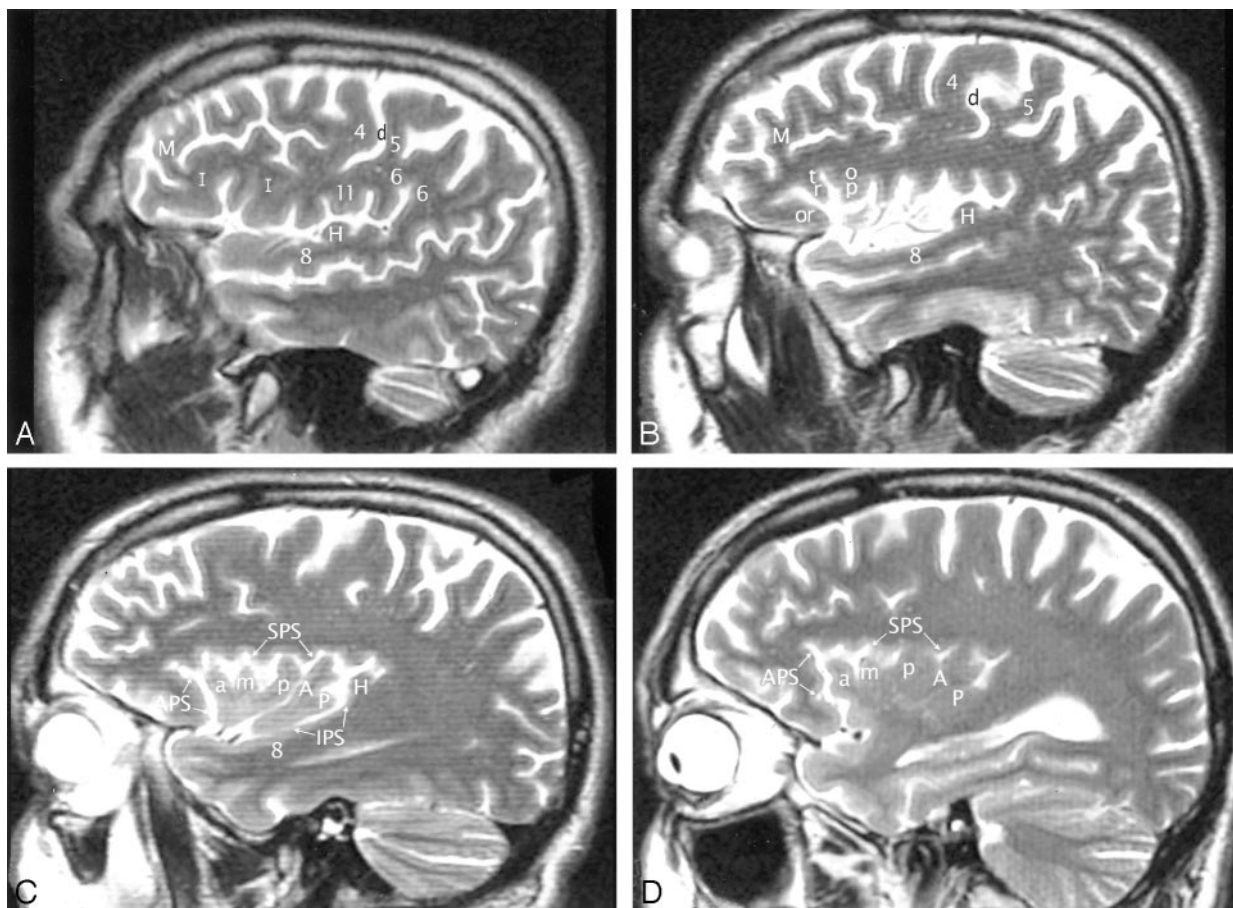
A–D, Imaging anatomy of the normal insula in a 51-year-old man. Sequential sagittal T2-weighted MR imaging sections from lateral (A) to medial (D) demonstrate the anterior (APS), superior (SPS), and inferior (IPS) PS, the ASG (a), MSG (m), and PSG (p) of the larger anterior lobule, and the ALG (A) and the branched configuration of the PLG (P) of the smaller posterior lobule. The CS (d) courses across the convexity between the precentral gyrus (4) and the postcentral gyrus (5) and then curves across the insula between the corresponding gyri of the insula (ie, between p and A). The overlying opercula interdigitate with the insular gyri with no significant distortion of insular anatomy. The HG (H) lies immediately behind the PLG and marks the posteroinferior border of the insula. M indicates middle frontal gyrus; I, inferior frontal gyrus; 6, supramarginal gyrus; 8, superior temporal gyrus; and 11, subcentral gyrus. Other abbreviations as in Figs 1–4.
